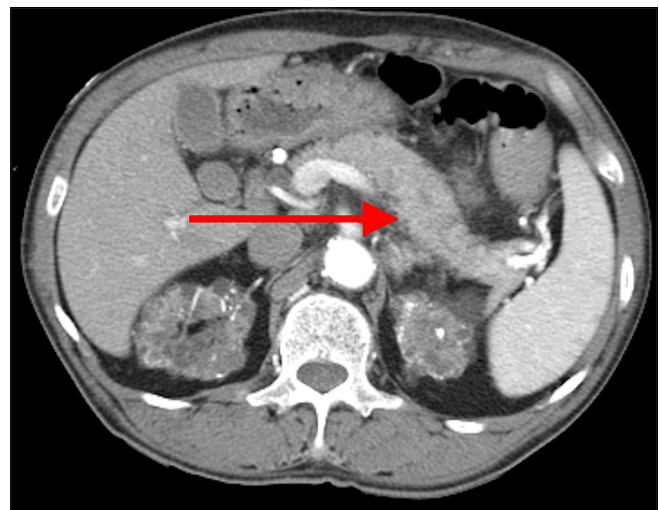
A 57-year-old man with polycystic kidney disease, end-stage renal disease, coronary artery disease, and bronchiectasis presented with refractory and massive hemoptysis. Ten hours after transarterial embolization, acute epigastric pain occurred, and contrast-enhanced computed tomography of the abdomen revealed mild swelling with blurred contours at the pancreatic body, suggestive of acute pancreatitis (red arrow).
